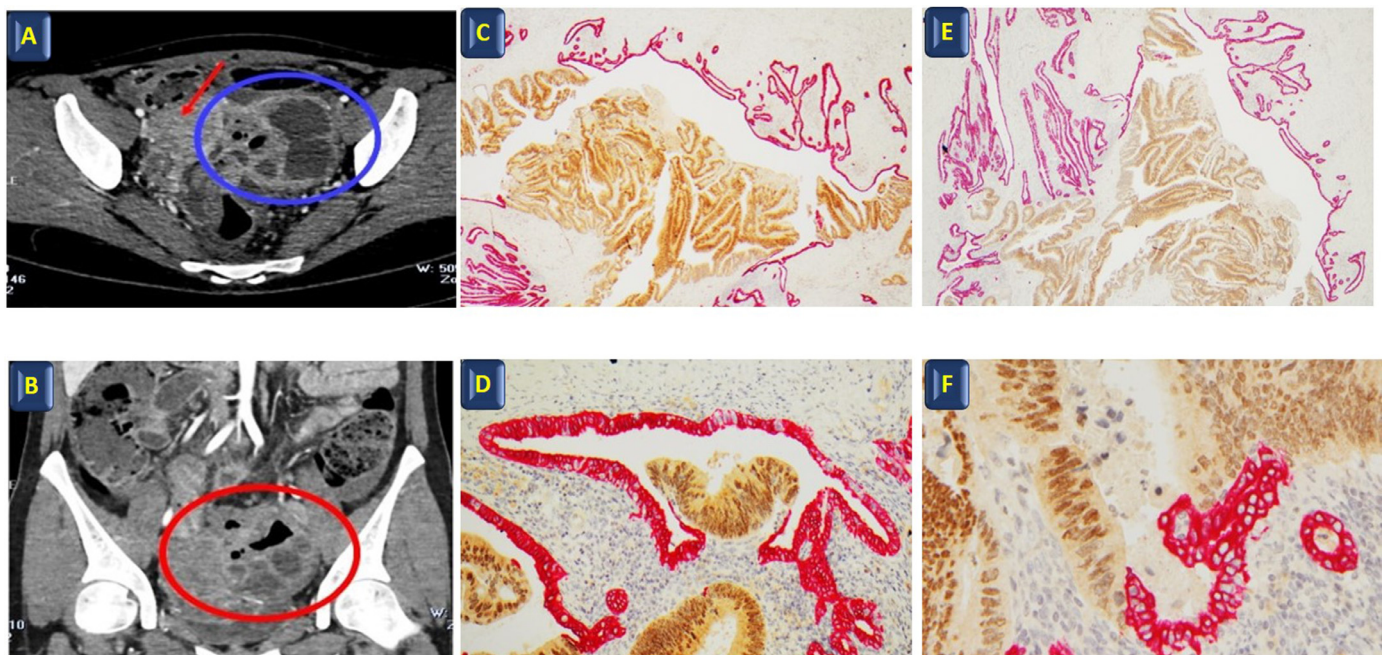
A-B: Coronal and axial CT scans after contrast injection showing an air-containing left ovarian mass (circle) adhering to the sigmoid colon and displacing the uterus (red arrow).
